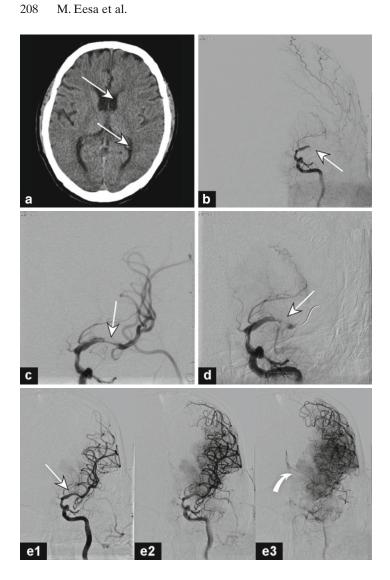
A 71-year-old man with hypertension, hyperlipidemia, tobacco abuse, and peripheral vascular disease was admitted through the Emergency Department with progressive right hemiplegia and global aphasia of 2-h duration. The NIH Stroke Score was 23. (a) a non-enhanced CT brain scan showed early edema in basal ganglia structures and less than one third of the left middle cerebral artery distribution (arrows). The patient received full-dose intravenous rt-PA (0.9 mg/kg) in the ED. (b) When the patient showed no signs of initial improvement, he was triaged for emergency catheter arteriography. Left internal carotid arteriography in the frontal projection during the arterial phase showed proximal occlusion of the left middle cerebral artery (arrow). (c) Initial attempts to perform mechanical thrombectomy were not successful. Balloon angioplasty was then performed restoring a thin channel for antegrade blood flow in the M1 segment of the left middle cerebral artery (arrow). (d) Repeat arteriography shows re-occlusion of the left middle cerebral artery despite systemic anticoagulation with rt-PA (arrow). (e) Stent angioplasty was then performed using a $4.5 \times 14 \text{ mm}^2 \text{ self-}$ expanding nitinol stent on a compassionate basis (arrow). Successive angiographic images show dramatic reperfusion of the left middle cerebral artery with luxury perfusion (curved arrow) in the basal ganglia indicative of tissue injury and loss of autoregulation. At the time of discharge to rehabilitation, the patient had moderate hemiparesis (strength 4+/5) and resolving expressive aphasia
